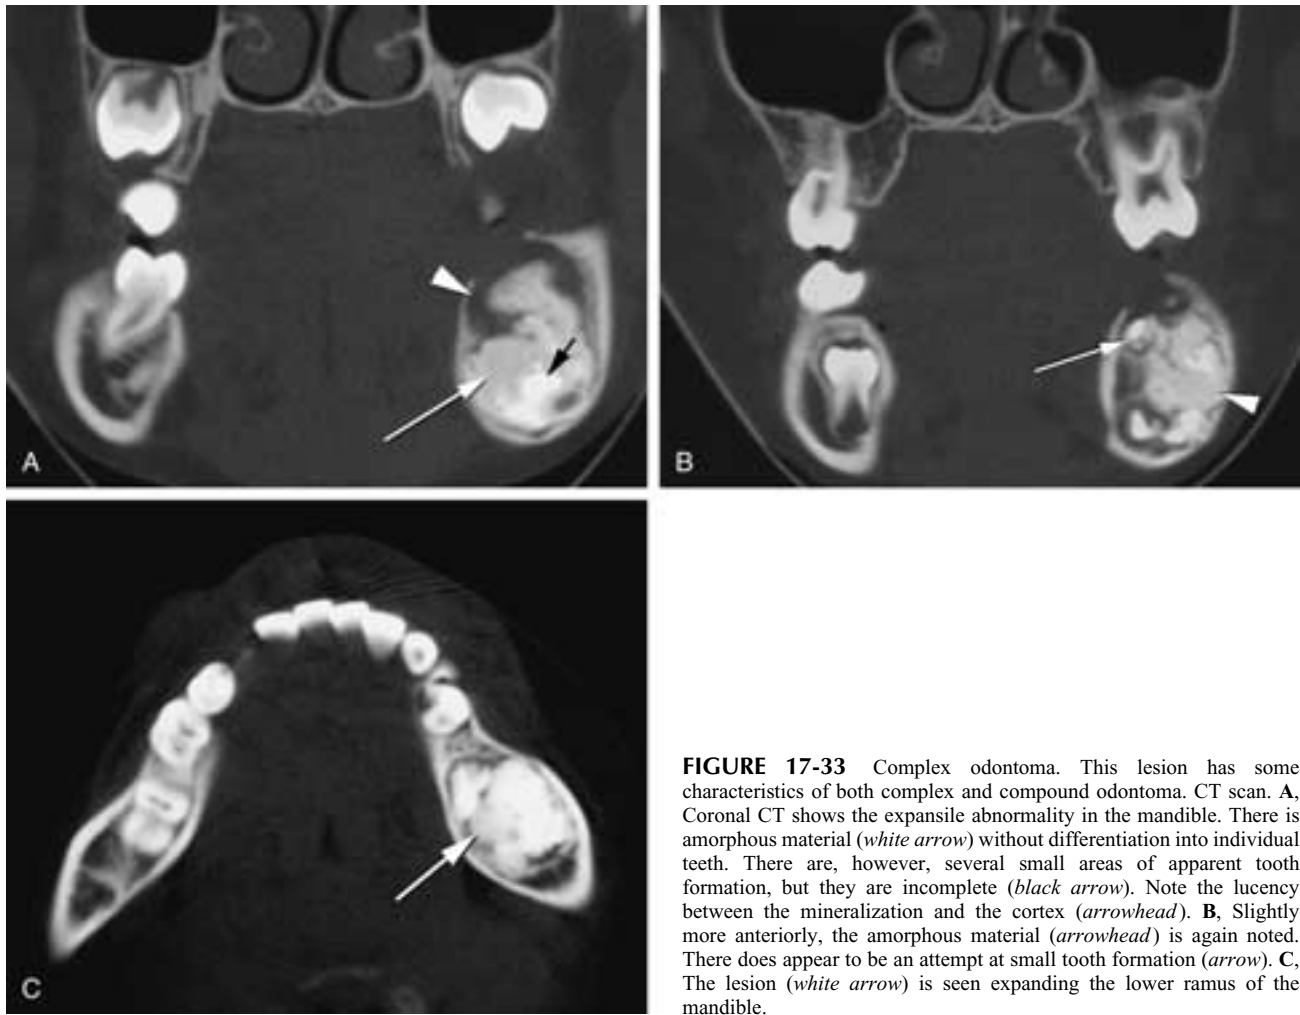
Complex odontoma. This lesion has some characteristics of both complex and compound odontoma. CT scan. A, Coronal CT shows the expansile abnormality in the mandible. There is amorphous material (*white arrow*) without differentiation into individual teeth. There are, however, several small areas of apparent tooth formation, but they are incomplete (*black arrow*). Note the lucency between the mineralization and the cortex (*arrowhead*). B, Slightly more anteriorly, the amorphous material (*arrowhead*) is again noted. There does appear to be an attempt at small tooth formation (*arrow*). C, The lesion (*white arrow*) is seen expanding the lower ramus of the mandible.
